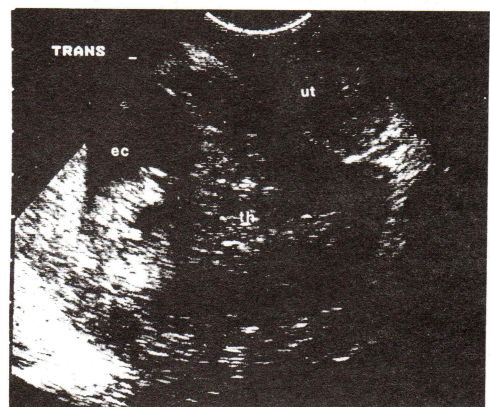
Transverse transvaginal sonography confirms an empty uterus (ut), right extrauterine gestational sac with viable fetus (ec) and thrombus in the region of the cul-de-sac (th) in a ruptured right tubal pregnancy.
